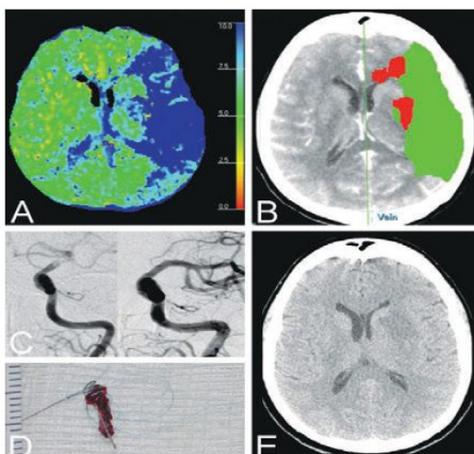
CT Angiogram, B:CT image showing infarct(red), penumbra(green).
